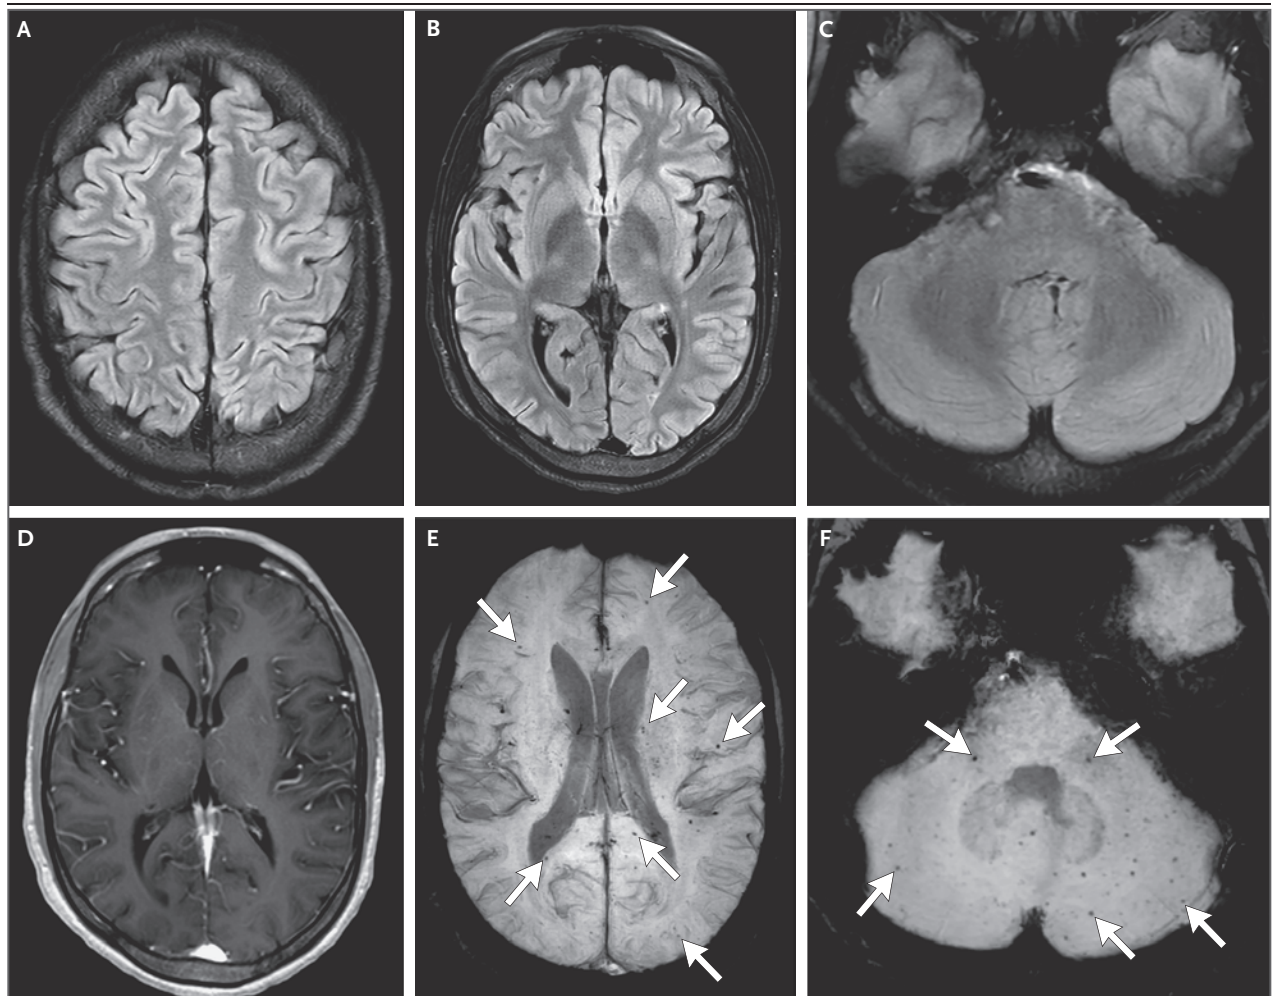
Follow-up MRI of the Head.
